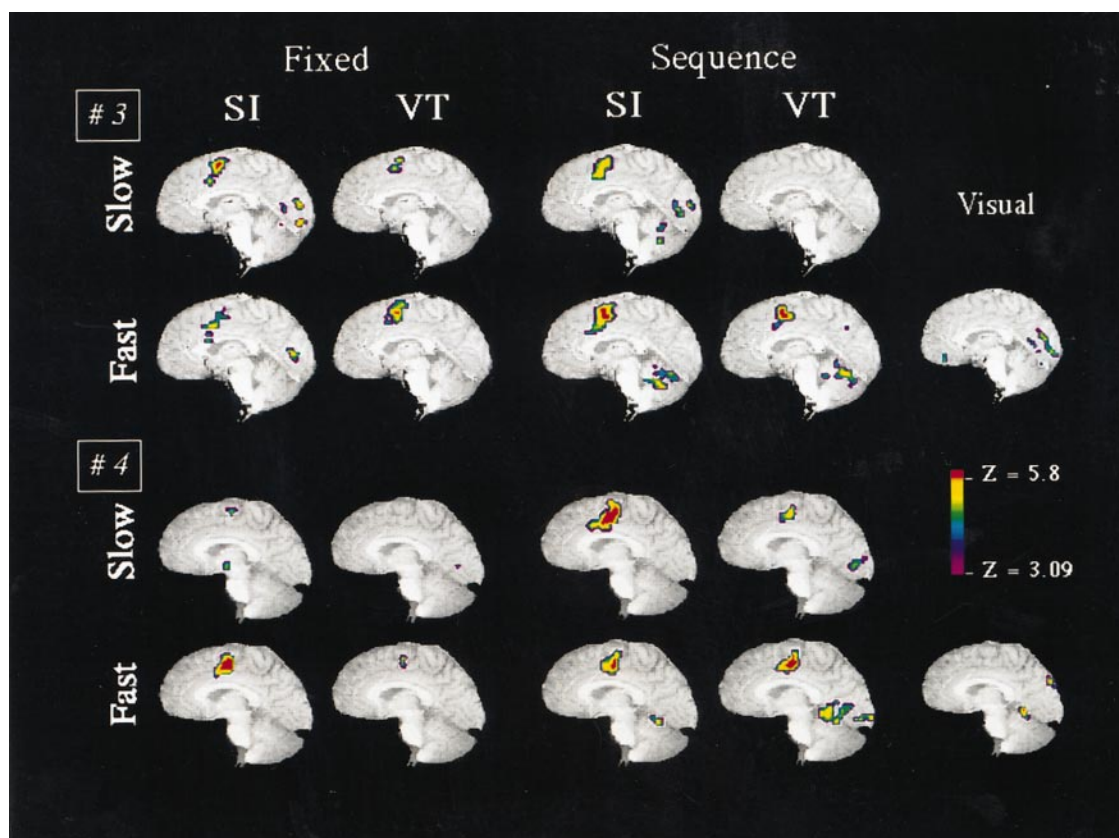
Cluster maps of significant cerebral activation in 2 subjects, for each condition. 3 (2 top rows): subject 3; 4 (2 bottom rows): subject 4. For each subject, the clusters are superimposed on the high-resolution MR image of the more medial sagittal slice in the left hemisphere. Conventions as in Fig. 2.
